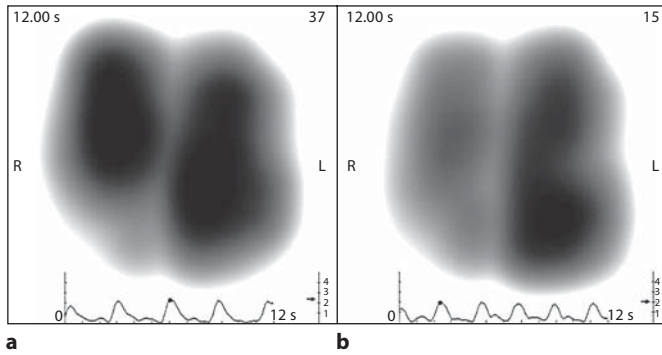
MEF images of a female patient with pleural effusion of 700 ml in the right lung. a MEF before drainage shows a lack of vibration response that created a triangle shape in the lower right lung, corresponding with the location of accumulated fluid on chest radiograph. b After drainage, the response in the lower right region increased considerably.
